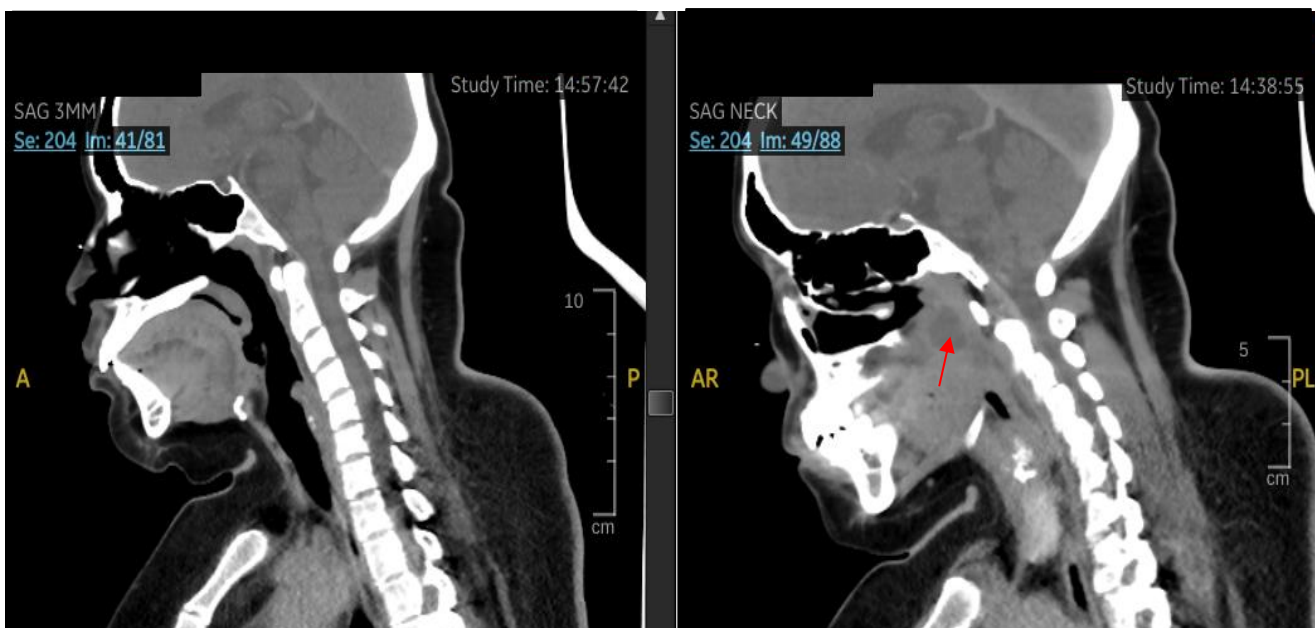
Sagittal view CT neck, film on the right shows abscess in the left lateral nasopharyngeal wall which tracts down the submucosally with associated mucosal edema and loss of lordosis of the cervical spine suggestive of prevertebral muscle spasm, features which are absent in earlier film (left)
